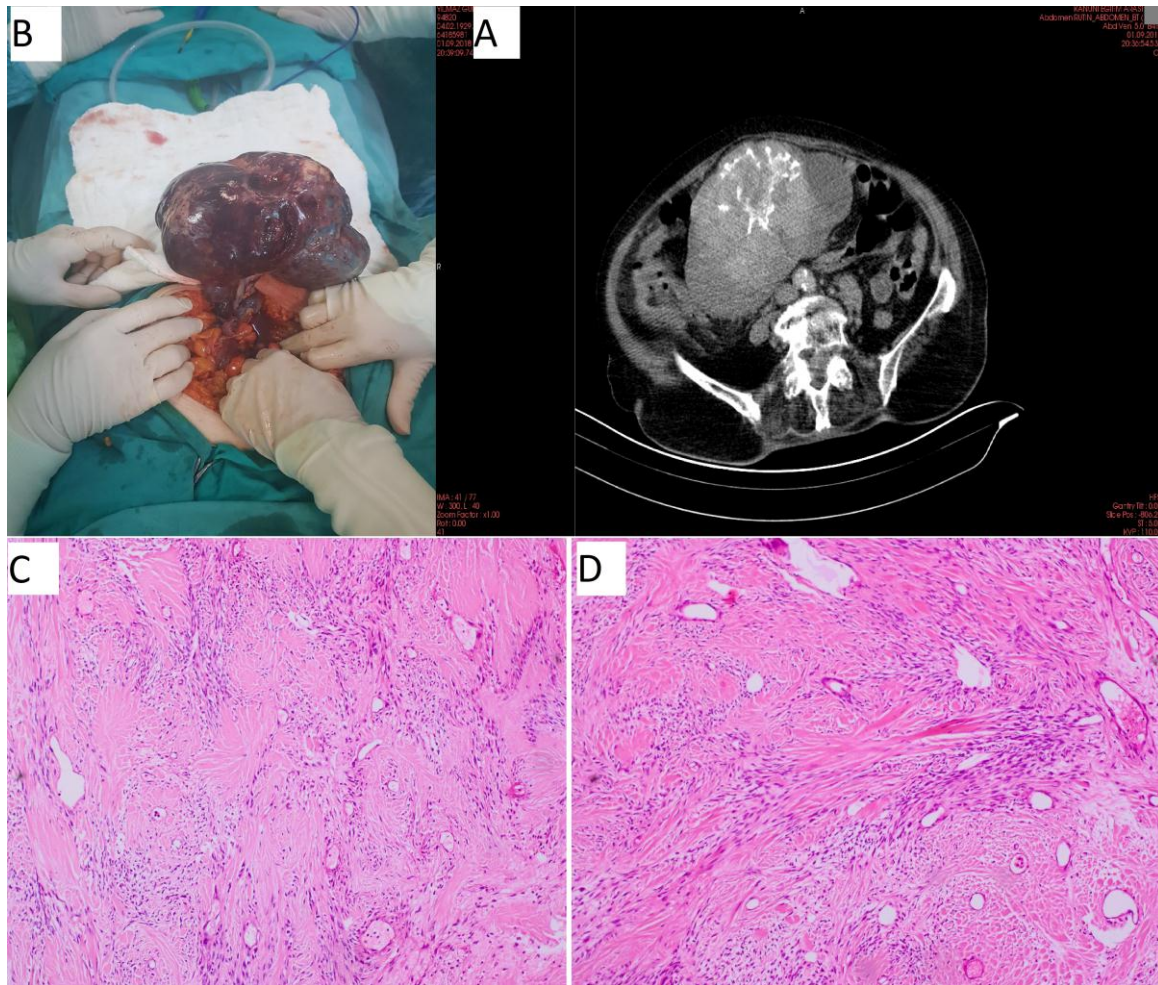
It can be seen approximately 20x25 cm, right-oriented, tumoral mass with solid component and irregular surface in CT
